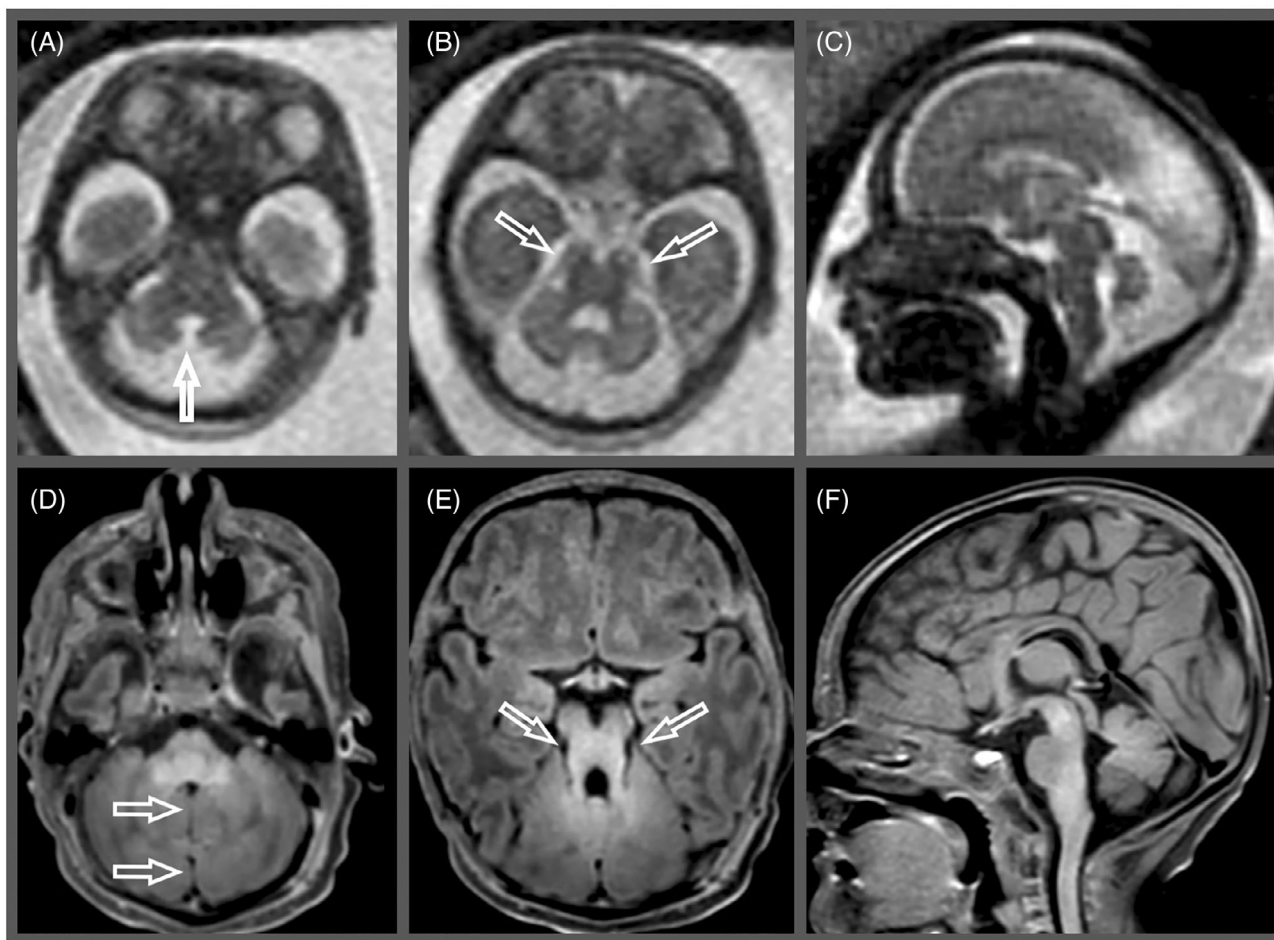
Molar tooth sign. (A–C) Fetal MRI at 21 GW and (D–F) corresponding neonatal MRI (D/E/F) in a patient diagnosed with Joubert syndrome. (A) and (B) axial T2-weighted images show hypoplasia of the vermis with large communication between the fourth ventricle and cisterna magna (arrow, A) and subtle molar tooth sign (axial, B); (C) sagittal T2-weighted image shows mildly hypoplastic vermis. Postnatally, there is evidence of hypoplasia of the inferior cerebellar vermis with a midline cleft (arrows, D) and thickened and elongated superior cerebellar peduncles forming the “molar tooth” appearance in the axial plane (arrows, E). Notice mildly hypoplastic vermis with coarse foliation (F).
